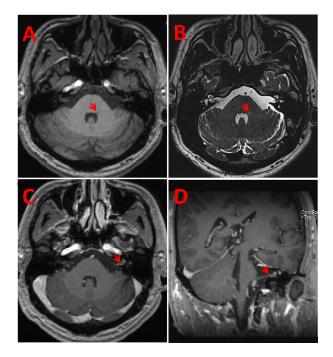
MRI results of patient 2. MRI showed low T1-MPRAGE and high T2 (3D-CISS) in the left brachium pontis (A,B). The facial nerve and vestibular nerve in the central canal showed an enhanced sign in head MRI (red arrow), and the brain stem showed no abnormal enhanced signal (C,D).
